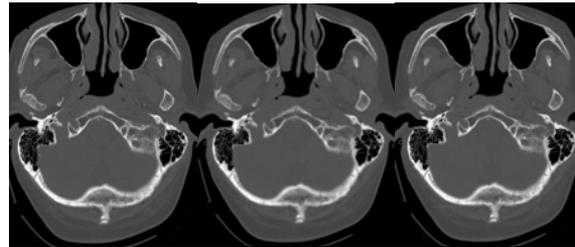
Bone window settings (W 2500 L 480). Axial CT images obtained with bone (A), standard/soft tissue (B), and hybrid (C) convolution kernels. Note the non-displaced fracture of the occipital bone without underlying intracranial hemorrhage.
